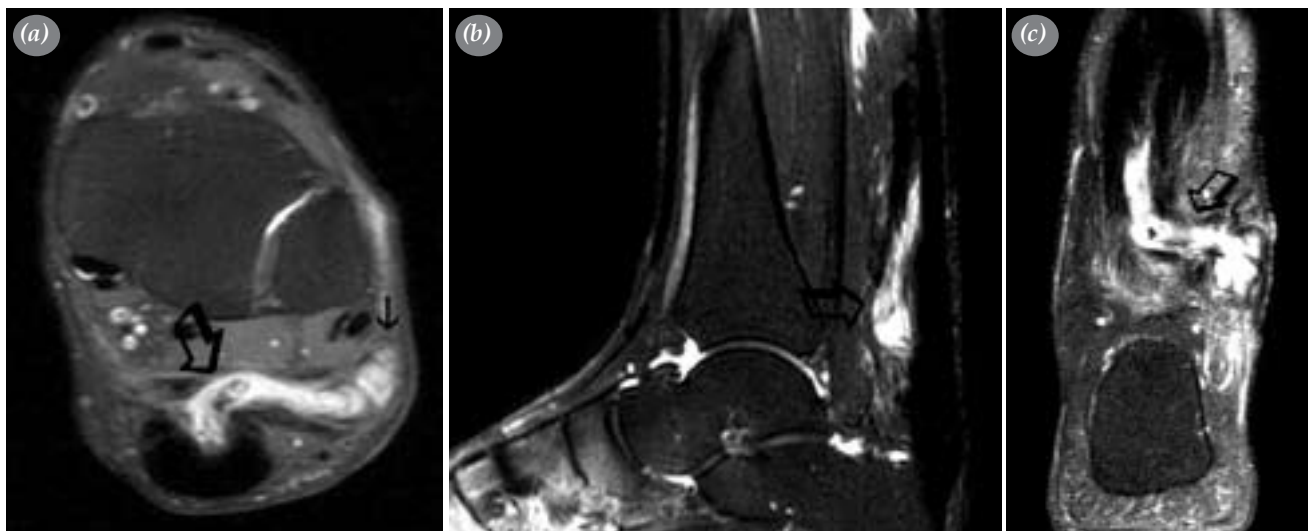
(a) Sagittal MRI view of the drained tract; bold arrow show suture material, thin arrow show outlet. (b) Fluid collection and tract. (c) Frontal MRI image of tract and suture material.
